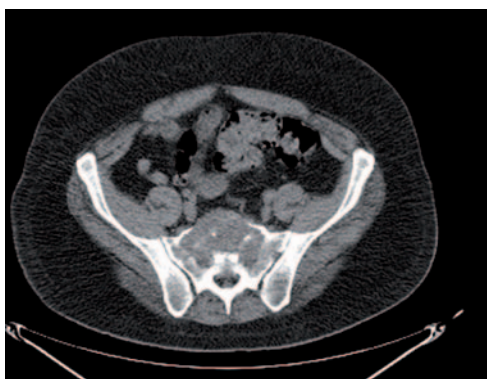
25-year-old man presented with back pain. Computed tomography of the abdomen demonstrated a right-sided renal tumor (A) with a large destructive lesion in the sacrum (B, C). CT did not demonstrate any other metastatic disease. A FDG-PET scan was performed (C) prior to palliative sacral surgery for intractable bone pain. FDG-PET did not demonstrate activity in the primary tumor but uptake was demonstrated in the metastatic sacral deposit.
